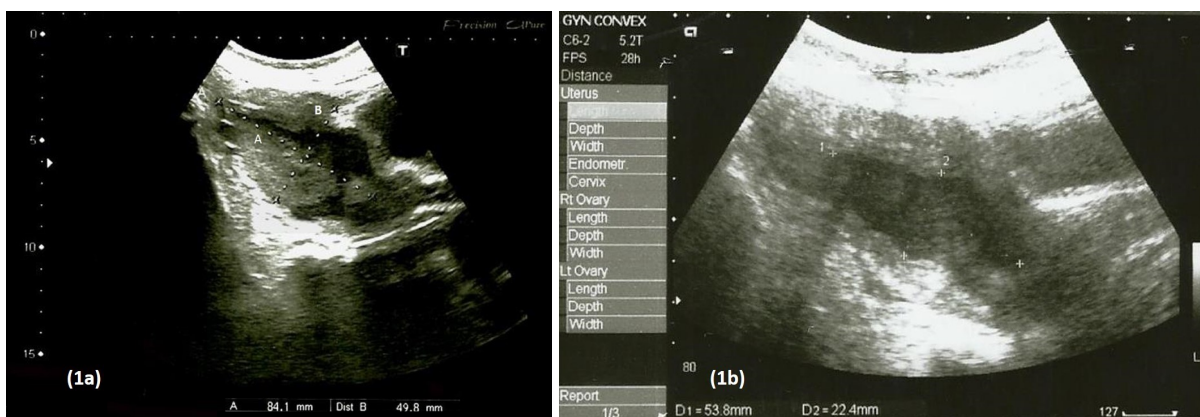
(a) Pelvic ultrasound showed an enlarged uterus measuring 9.1cmx4.7cm with a collection inside uterine cavity (3.5cmx7.2cm). The myometrium thickness was measured at 1.5cm. (b) Pelvic ultrasound performed 1 month post discharged showed residual pyometra after the hysteroscopy endometrial curettage.
